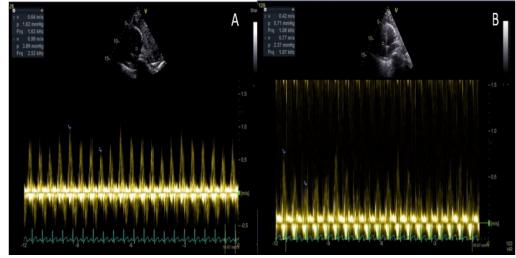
Doppler inflow velocity of mitral (A) and tricuspid (B) demonstrate exaggerated inflow variation of 37%, 83% respectively.
